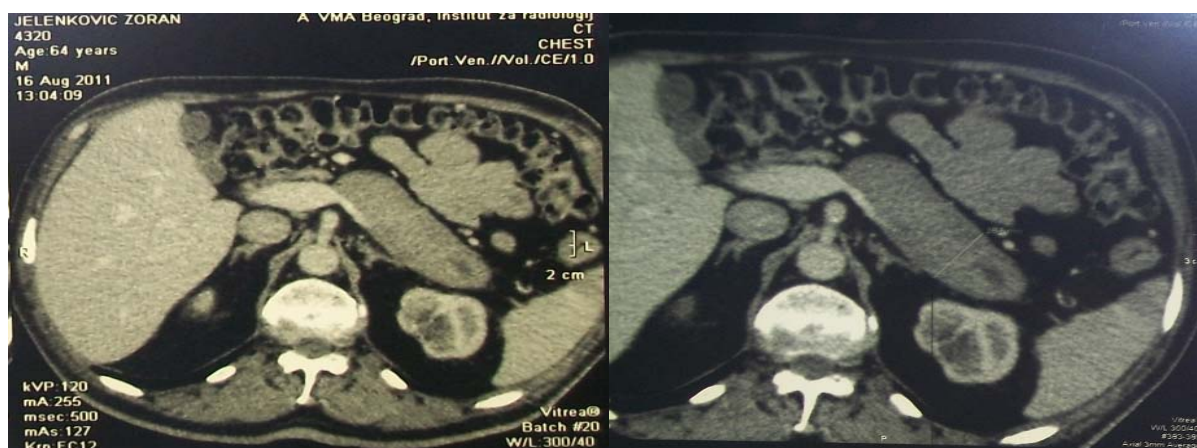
Multislice computed tomography of the pancreas with type 1 autoimmune pancreatitis.
